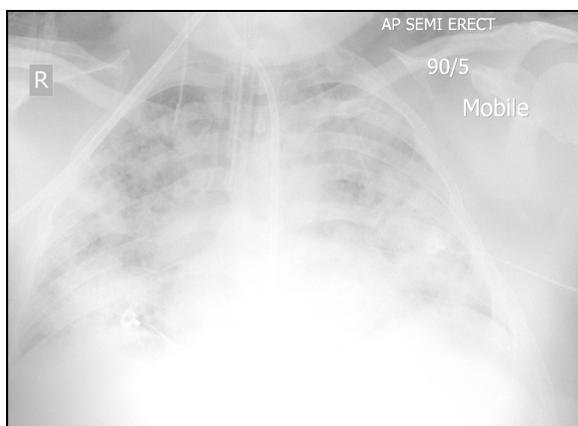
Repeated chest X-ray taken a few hours later in ICU after tracheal intubation. The x-ray image shows widespread interstitial shadowing which is consistent with ARDS.
